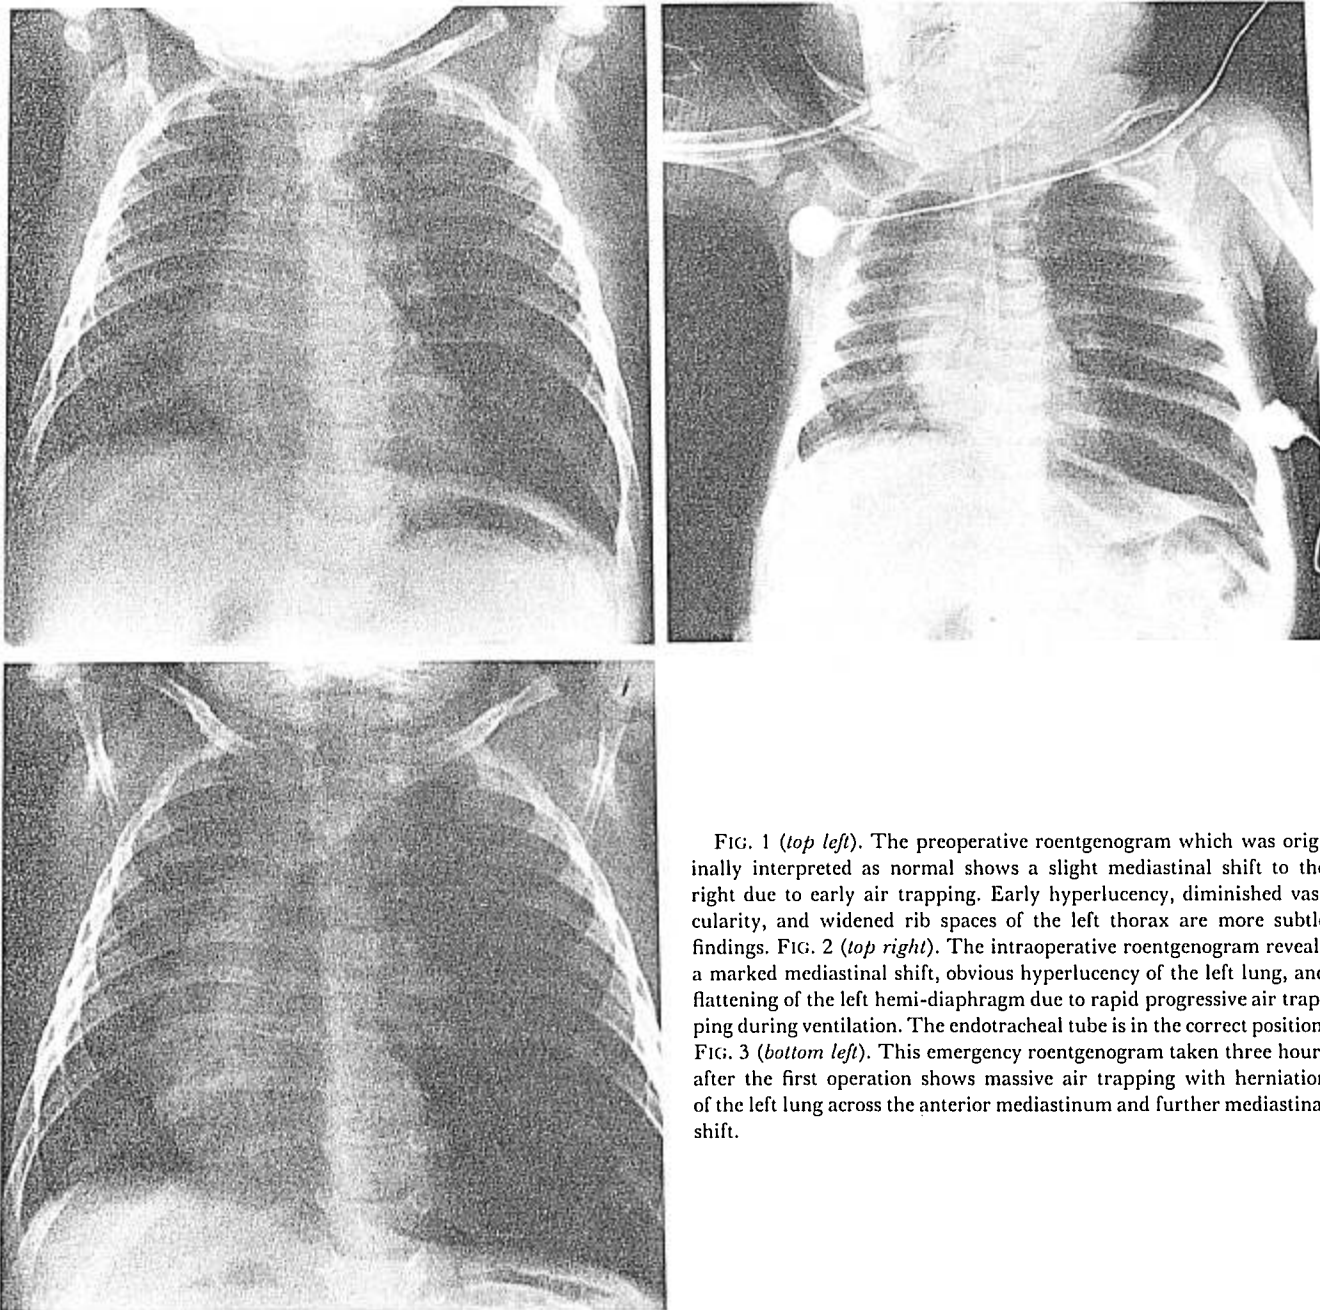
(*top left*). The preoperative roentgenogram which was originally interpreted as normal shows a slight mediastinal shift to the right due to early air trapping. Early hyperlucency, diminished vascularity, and widened rib spaces of the left thorax are more subtle findings. FIG. 2 (*top right*). The intraoperative roentgenogram reveals a marked mediastinal shift, obvious hyperlucency of the left lung, and flattening of the left hemi-diaphragm due to rapid progressive air trapping during ventilation. The endotracheal tube is in the correct position. FIG. 3 (*bottom left*). This emergency roentgenogram taken three hours after the first operation shows massive air trapping with herniation of the left lung across the anterior mediastinum and further mediastinal shift.
